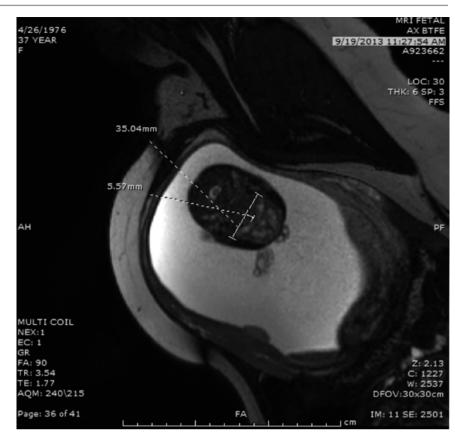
MRI image demonstrating the technique to obtain the jaw index. A line is drawn from the angles of the mandible and an orthogonal line is drawn to the mentum of the mandible. This later measurement is then divided by the biparietal diameter to yield a ratio that is multiplied by 100. A value less than the fifth percentile (jaw index < 24) would indicate fetuses at highest risk for airway compromise and when associated with glossoptosis and absence of fluid in the stomach would be an indication for EXIT-to-airway
